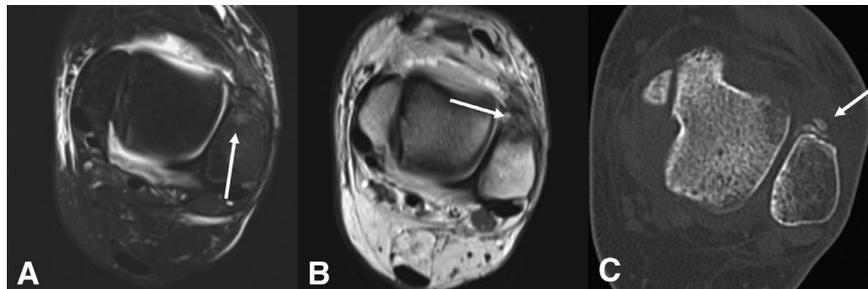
Bony avulsion injury associated with AITFL injury. Axial proton density fat saturated images (A) demonstrate subtle bone marrow edema at the anterior tubercle of the fibula (Wagstaffe-Leforte tubercle). Axial proton density images at the same level (B) demonstrate cortical disruption with loss of the normal hypointense cortical rim at the AITFL attachment on the fibula. Axial CT images at the same level better demonstrate a cortical avulsion fracture of the fibular attachment of the AITFL. AITFL, anterior inferior tibiofibular ligament.
